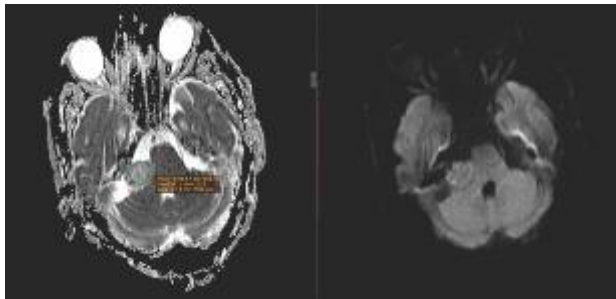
An MRI (DWI & ADC) image of a benign CP angle tumor (Schwannoma). An ellipse ROI placed over the tumor gives a mean ADC value of $1.4 \times 10^{-3} \text{mm}^2/\text{s}$
